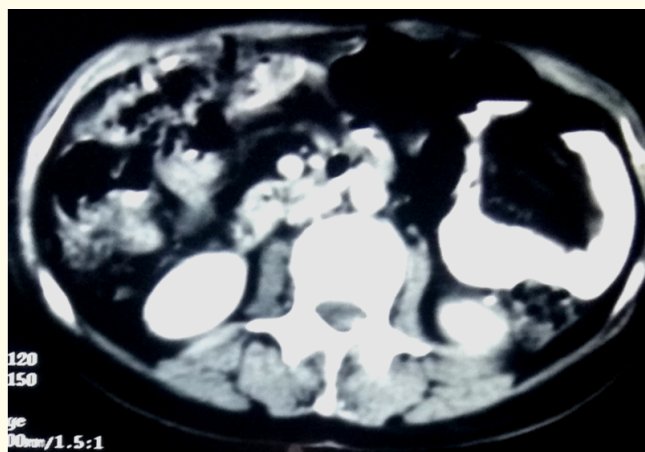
Images of Contrast CT Abdomen showing thick edematous bowel loops.
